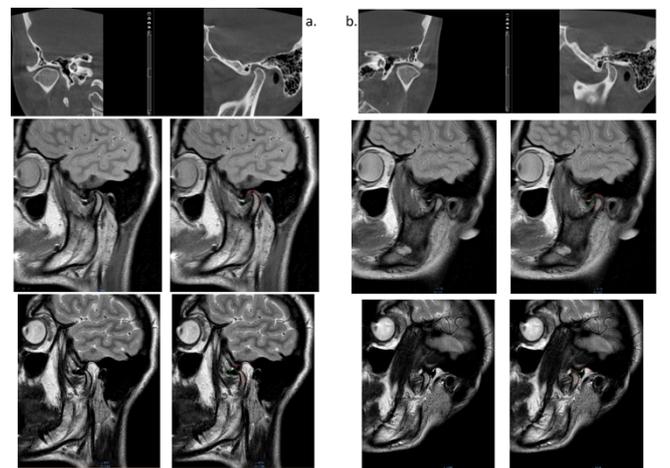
Computed tomography and magnetic resonance imaging of the TMJ. a. Right TMJ. b. Left TMJ.
